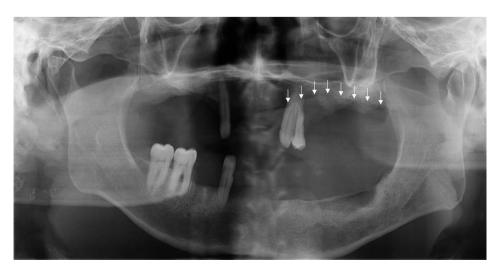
Panoramic radiograph shows a large tongue shadow (arrows).
